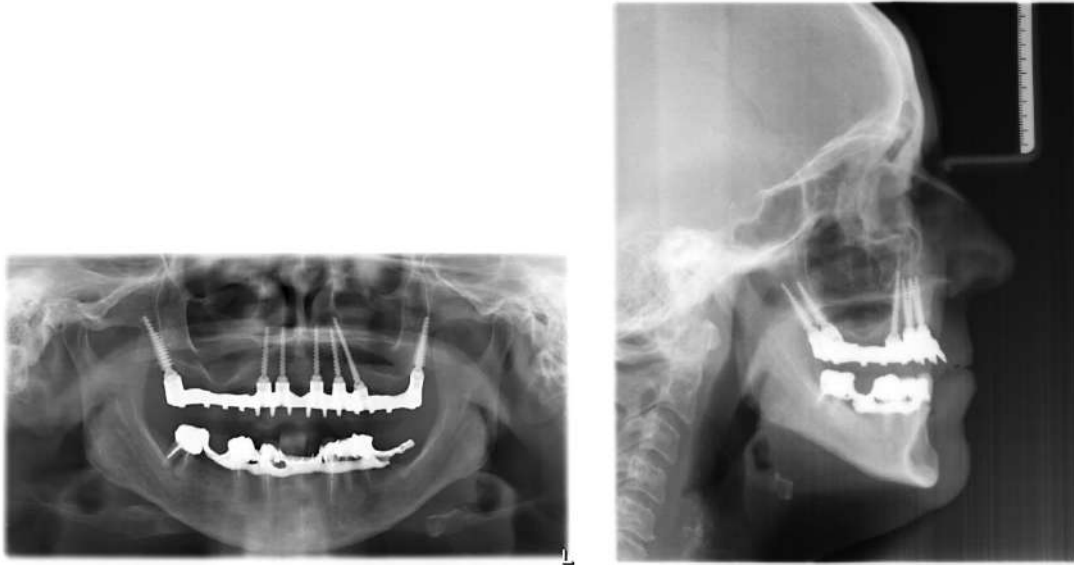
Panoramic radiograph of patient after implant placement
